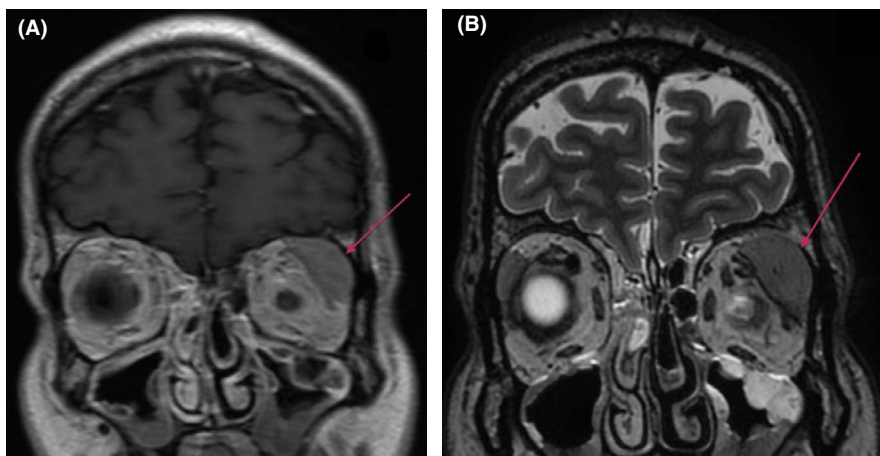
Brain MRI. (A) The left lacrimal gland shows hyperintensity on T1-weighted coronal imaging. (B) The left lacrimal gland shows isointensity on T2-weighted coronal imaging. (C) The left lacrimal gland shows high restriction on diffusion-weighted and diffusion-calculated (ADC) imaging
